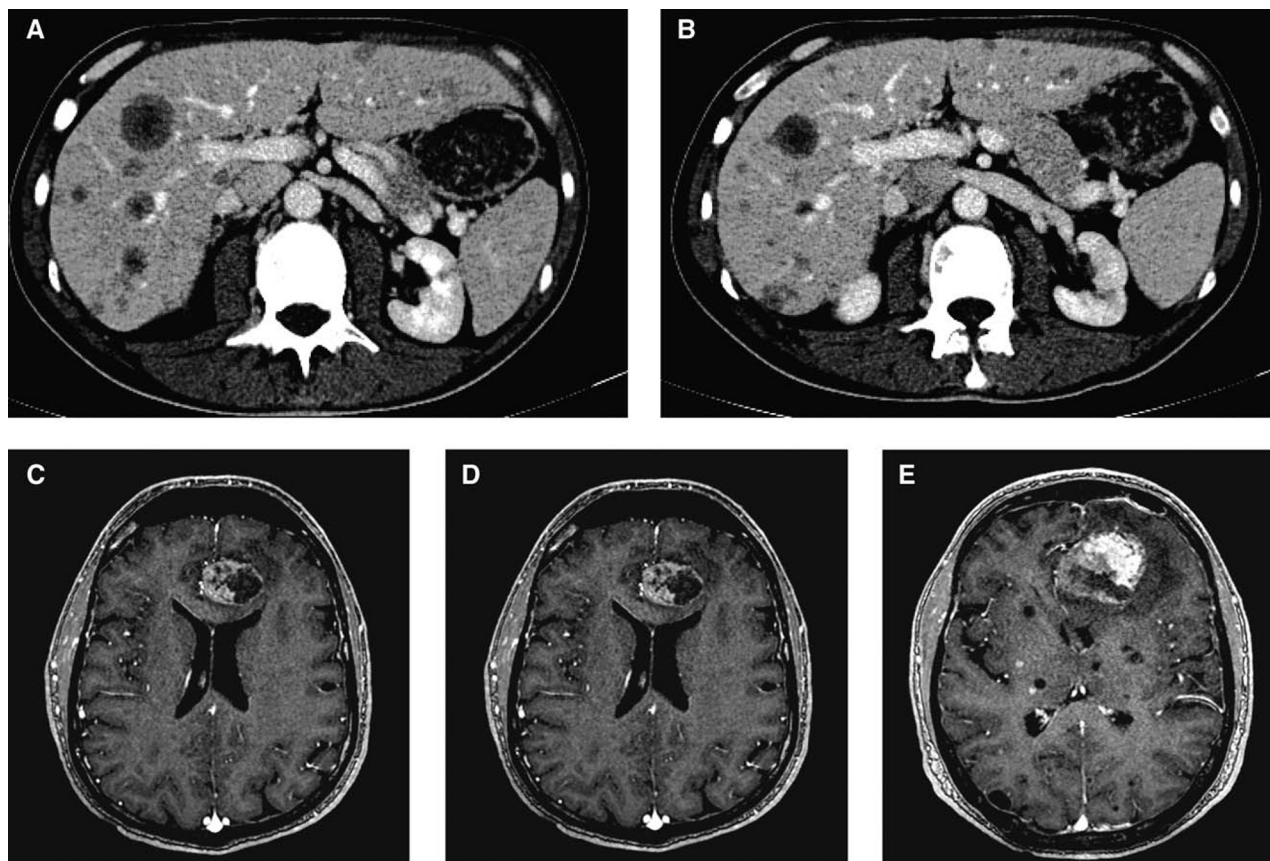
Abdominal computed tomography (A) before and (B) after 6 weeks of crizotinib showed a substantial decrease in the size of all liver metastases. C, D, and E, Magnetic resonance imaging T1 gadolinium at (A) initiation of crizotinib and after (B) 6 and (C) 10 weeks of treatment showed an increase in size of the left frontal cerebral metastasis of 28 mm to 54 mm associated with the appearance of a right periventricular lesion.
